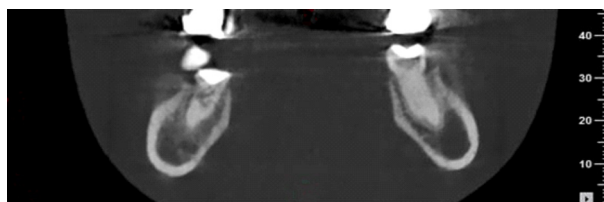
CBCT image of tooth 46 in coronal plane showing in this sectional representation an irregular ICR lesion situated in buccal area of coronal half of the distal root, having two lingually directed extensions. The condition seems to be less destructive than in sagittal and axial planes. However, it is confirmed the Class 4 category of ICR. CBCT: Cone-beam computed tomography; ICR: Invasive cervical resorption.
